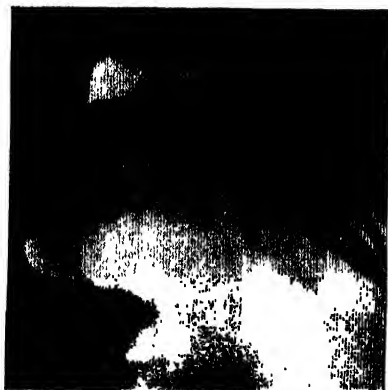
A 'lost' swab located by portable X-ray on the operating table during cholecystectomy.
